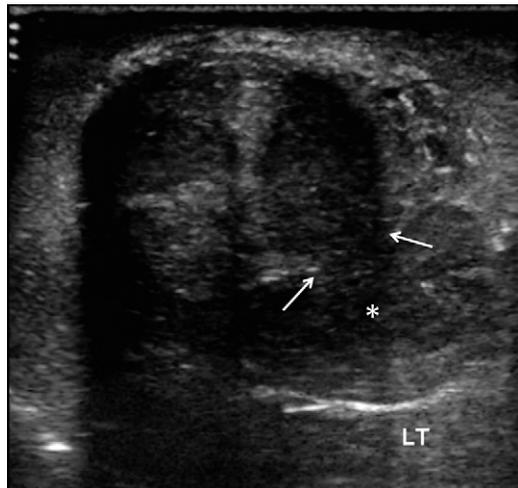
Ultrasound demonstrating penile fracture. (A) Transverse gray-scale image of the penis demonstrates lack of definition of the ventral aspect of the left corpus cavernosum consistent with fracture (arrows). Blood products and extruded corpus cavernosal tissue is seen ventrolaterally (white asterisk).
